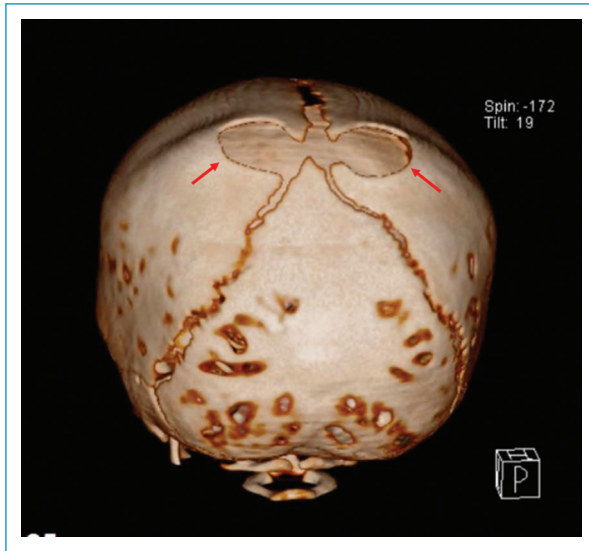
Cranial CT-scan with 3D reconstruction demonstrating a bilobed bone (red arrows).
